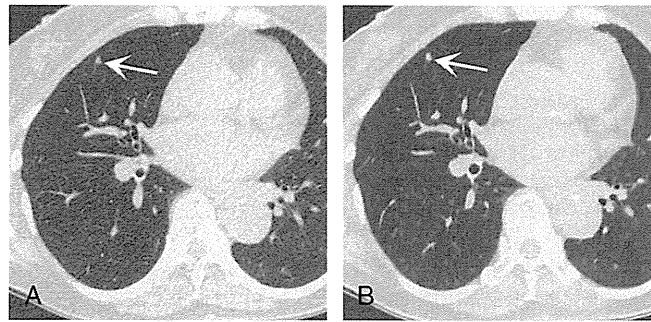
Imaging results of a 64-year-old woman (weight, 52 kg): A, Low-dose CT (DLP, 36.4 mGy-cm) reconstructed with ASIR. B, Ultralow-dose CT (DLP, 14.0 mGy-cm) reconstructed with MBIR. Both images provide adequate visualization of the solid nodule in the right middle lobe (arrows), which was identified by both radiologists.
